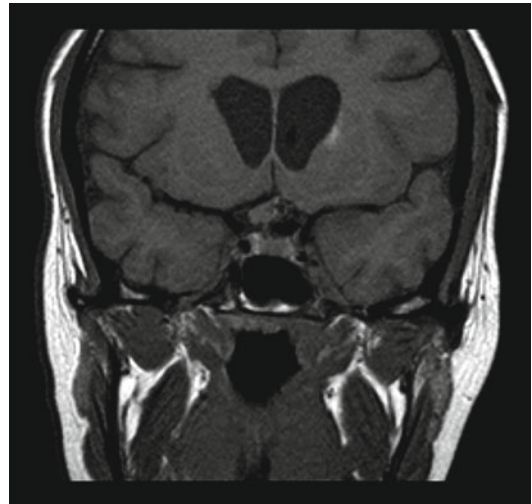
MRI T1 sequence shows a small medial clinoid aneurysm compressing the pituitary stalk
